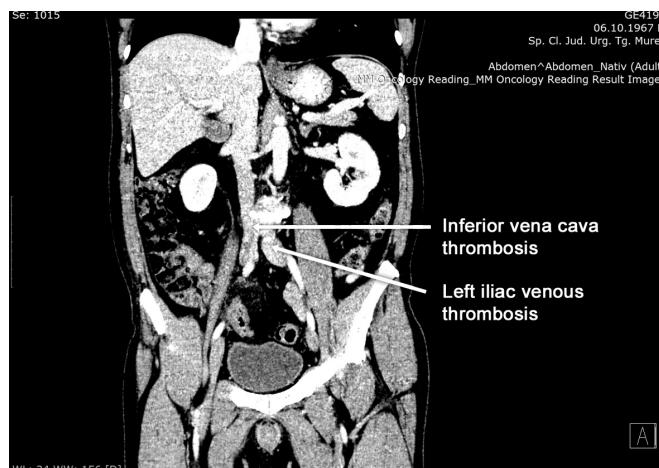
Contrast-Enhanced abdominal CT examination – visualisation of the thrombus in the inferior vena cava and in the left common iliac vein (arrows)
